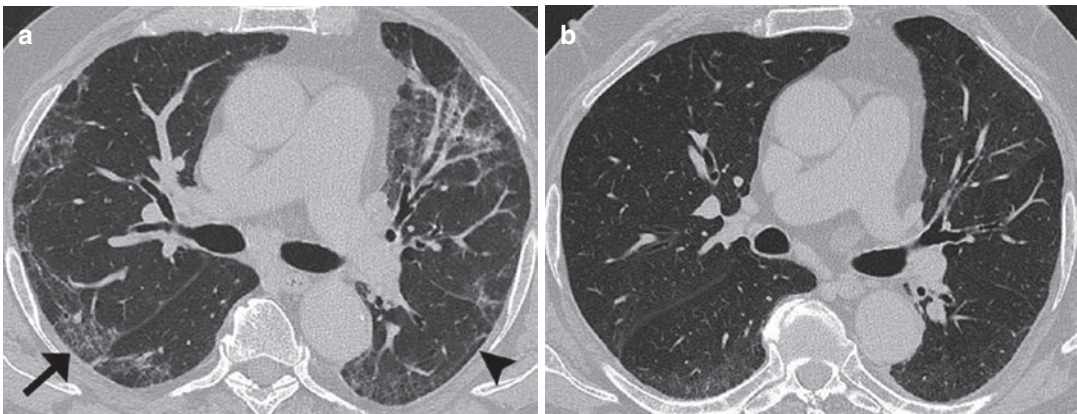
(a, b) Axial CT image in a 61-year-old man with NSIP shows bilateral subpleural irregular linear opacities (arrowhead) and ground-glass opacities (arrow) (a).
